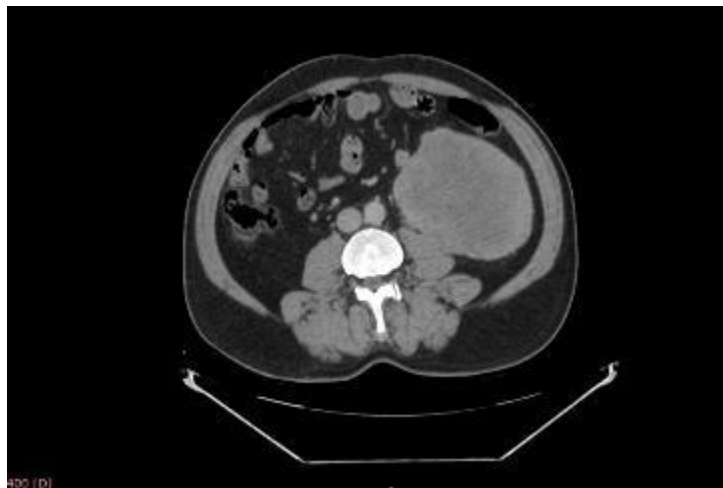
Axial contrast-enhanced CT image showing a large, encapsulated lower pole left renal mass with central necrosis and mild perirenal fat infiltration, without vascular or extracapsular extension
